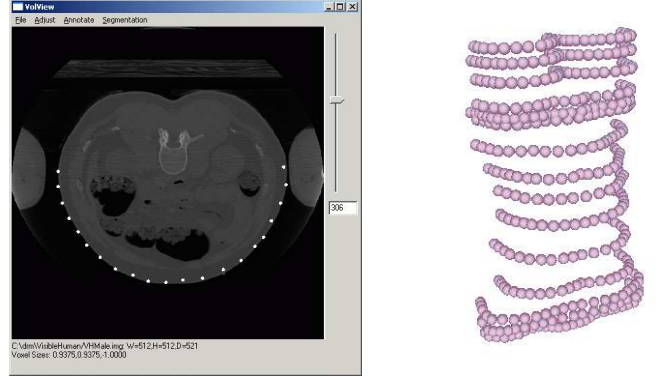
Hand annotation of surface in CT volume
